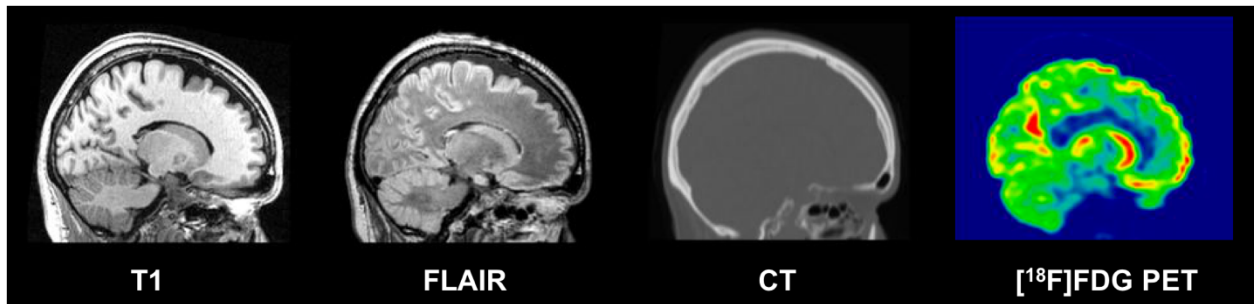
Example of normalized T1 MRI, FLAIR MRI, CT and [¹⁸F]FDG PET images (sagittal plane) in MNI space, for one subject of the database
